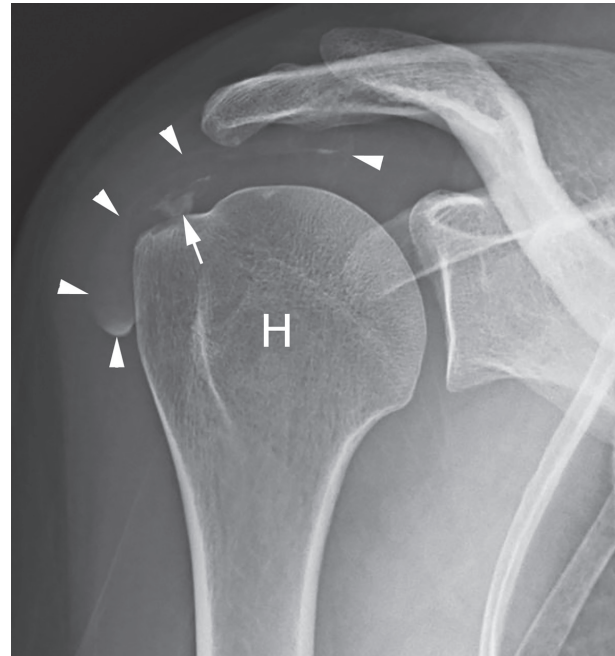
Calcific tendinopathy of the supraspinatus (arrow). In this case, most of the calcification has drained into the subacromial-subdeltoid bursa (arrowheads), which can be easily seen on conventional radiograph. H=humeral
